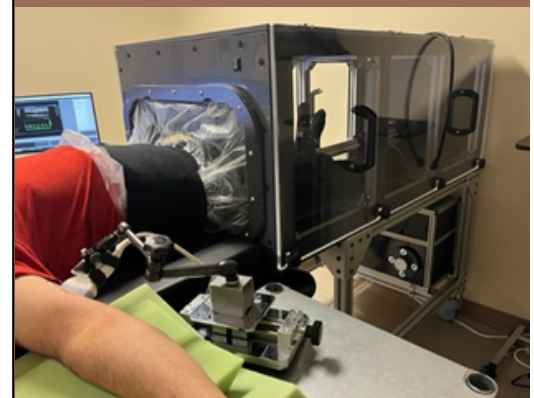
shows how endothelial function of the brachial artery in the arm is examined using ultrasound. The lower-body negative pressure (LBNP) box is used to stimulate sympathetic activity that causes closure of the arteries (vasoconstriction). LBNP is used at rest and during exercise to test vascular function.
